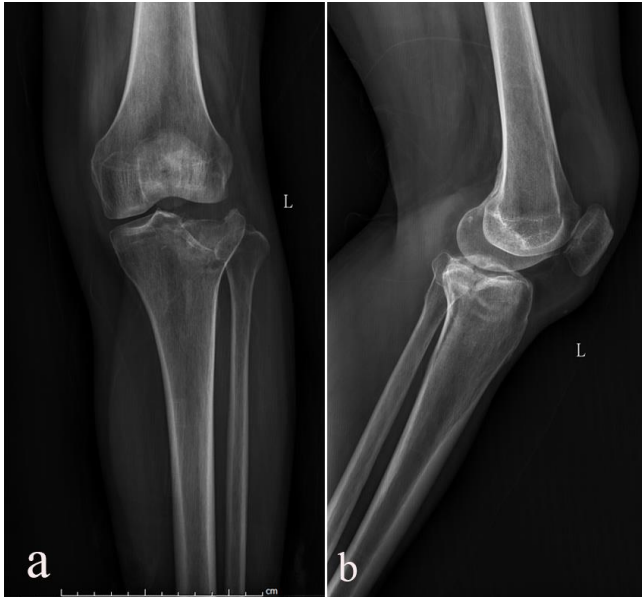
A 54-year-old female sustained from an electric bicycle accident was surgically treated through the anterolateral approach. a, b Preoperative anteroposterior and lateral X-ray views showed the collapse of the lateral part of tibial plateau.
